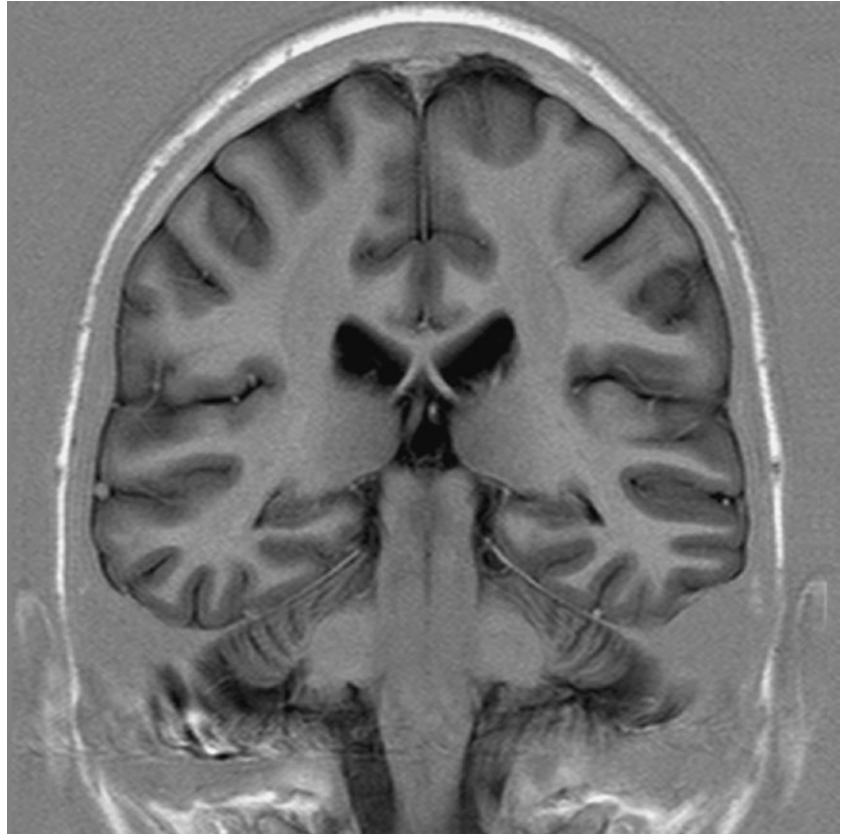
Coronal incoherent (spoiled) T1-weighted GRE image through the hippocampi acquired as part of a 3D acquisition.
